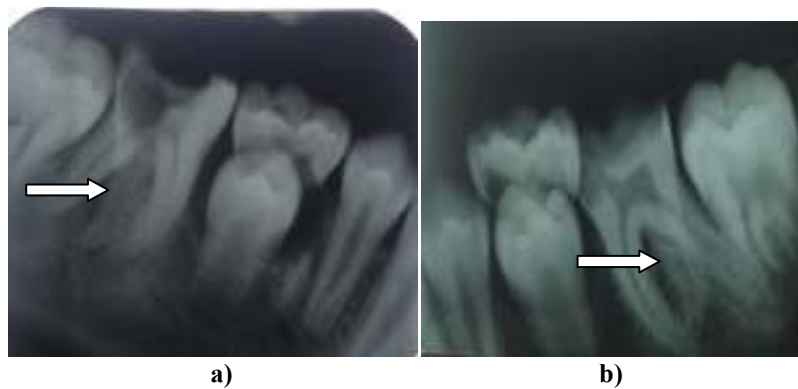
Radiographs showing three roots, a) 46, b) 36.
